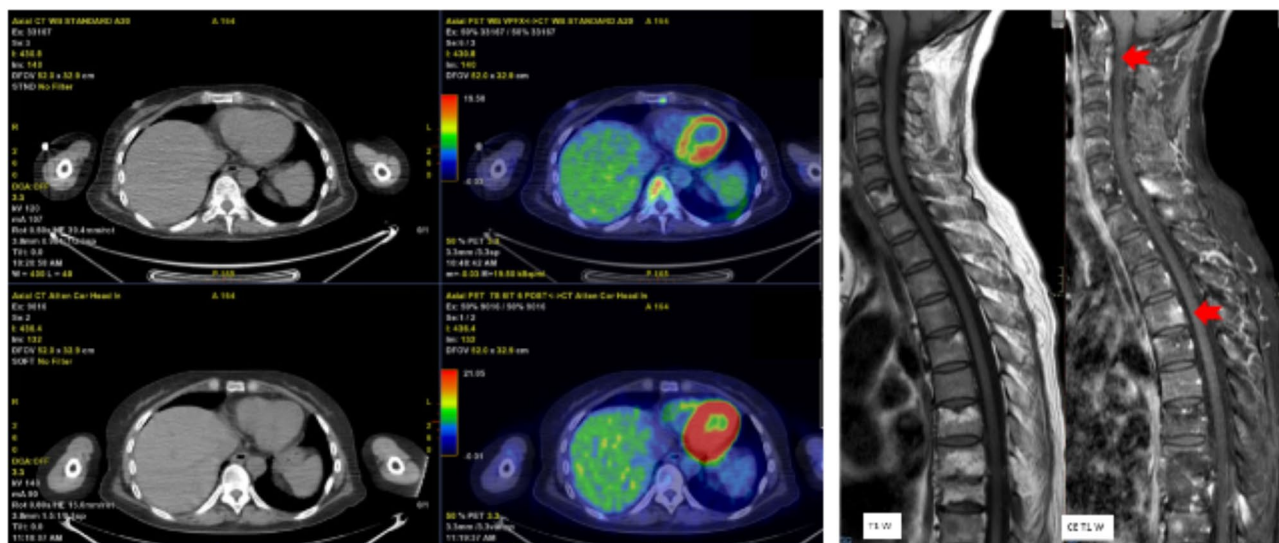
MRI and PET scan showing splenic and skeletal involvement
